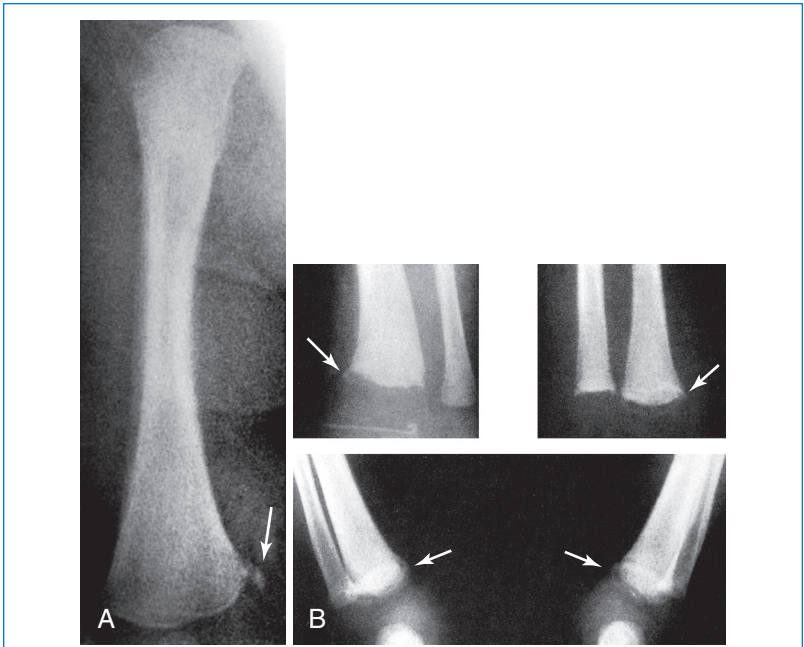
Metaphyseal fractures. Radiographs of the right femur (A) and both ankles (B) of a 2-month-old abused infant demonstrating metaphyseal corner fractures of the distal femur and both distal tibia (arrows). The angled tangential view reveals the “bucket handle” appearance of the fracture. (From Adam A, et al. Grainger & Allison’s diagnostic radiology, 5th ed. Edinburgh: Churchill Livingstone, 2008, Fig. 68-24.)
